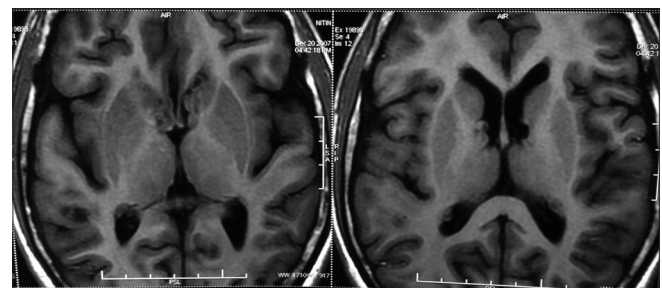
MRI scan showing subependymal tubers on T1 weighted image
